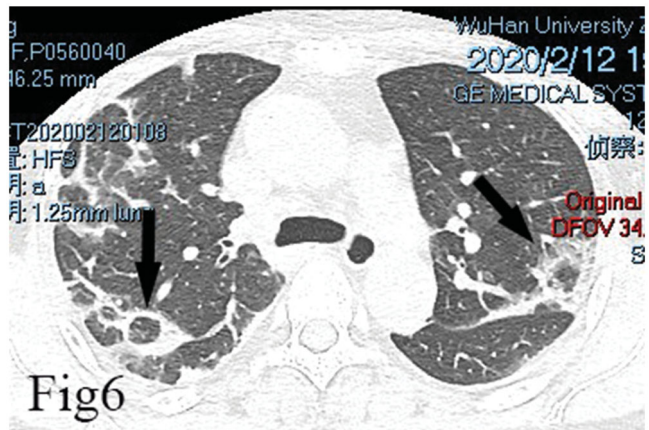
A 58 year old male patient diagnosed with mild COVID-19, with a chief complaint of “febrile and coughing for four days, shortness of breath for two days”. The CT showed reversed halo sign (black arrows) bilaterally.
